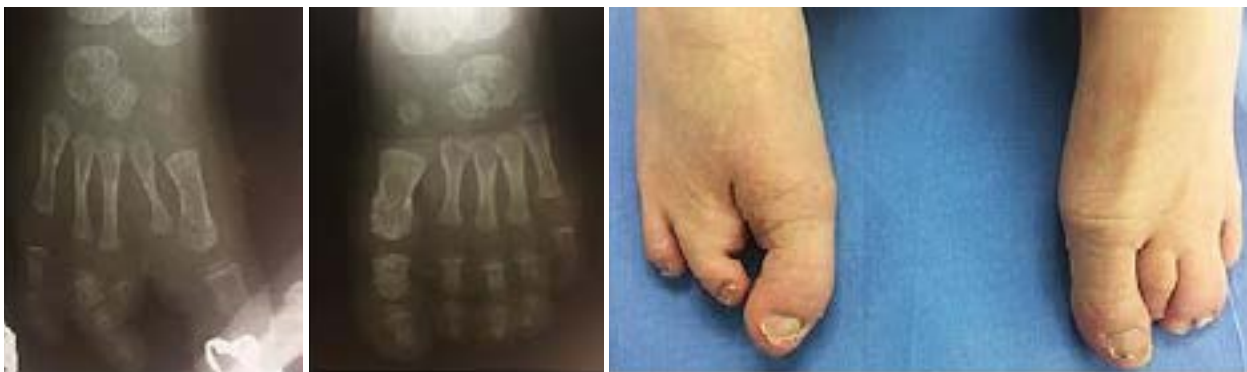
Current clinical presentation and previous radiographs of feet. On the right foot the proximal, middle and distal phalanges of the index toe are missing. The middle and distal phalanges of the middle toe on the right foot is also missing. On the left foot soft tissue union is visualised between the middle and fourth toe.
